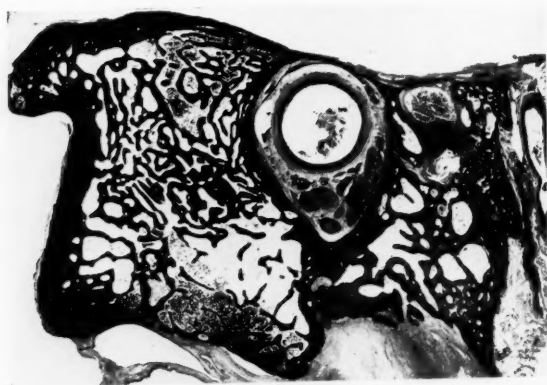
Most of the marrow in this entirely nonpneumatized petrous pyramid is of the fatty type (cf. Fig. 4). Comparisons of the bony framework of the region medial to the carotid canal in this figure with those seen in Figs. 4, 10 and 11 demonstrate one cause of variations in appearance of the roentgenograms of normal nonpneumatized petrous pyramids.
